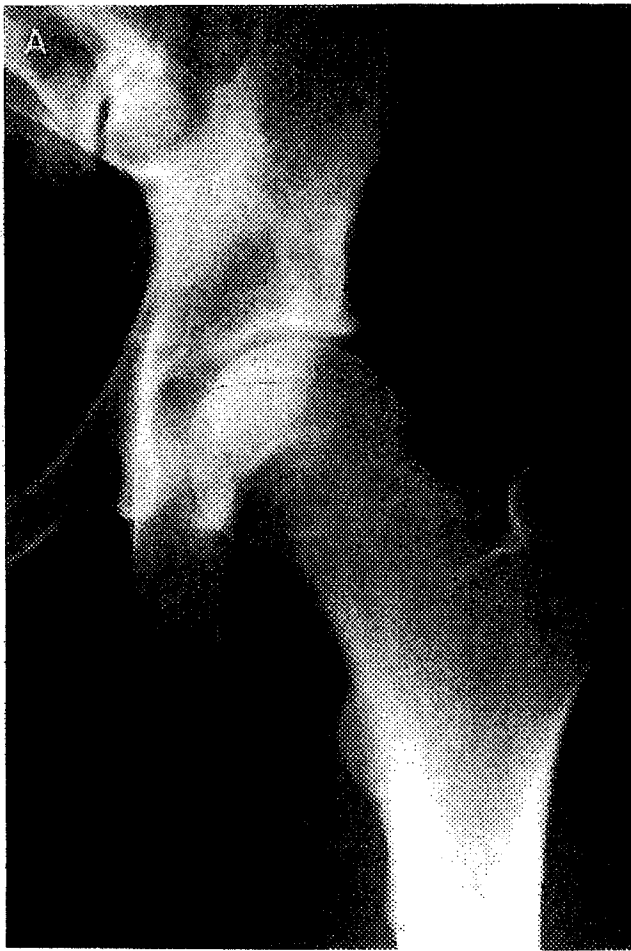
A 20-year-old male collegiate basketball player underwent arthroscopy for removal of an acute chondral fragment from the medial aspect of the femoral head. (A) AP radiograph shows no acute findings, but there is subtle evidence of underlying congenital changes, characterized by slight lateral uncovering of the femoral head. (B) Arthroscopic view from the anterior portal shows a partial detachment of the lateral labrum [L] from the bony acetabulum [A]. This is an incidental finding associated with his mild underlying dysplasia. This would be characterized as a detached labrum according to the work of Nishina et al.⁸
